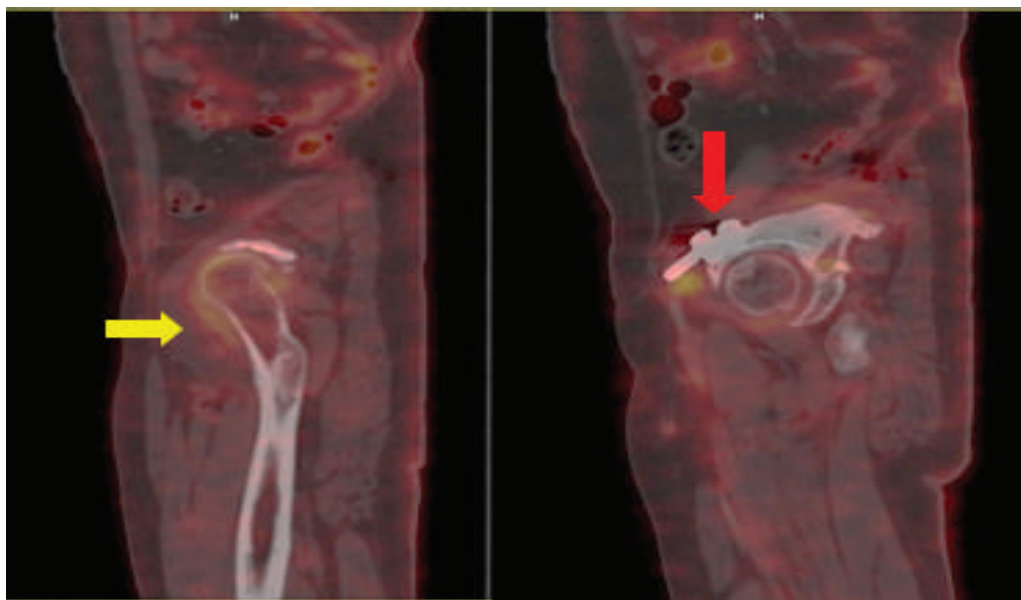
FDG PET/CT sagittal view showing the reconstructive hardware (red arrow) with surrounding low-grade FDG uptake (yellow arrow), indicating chronic post-surgical inflammatory response.
